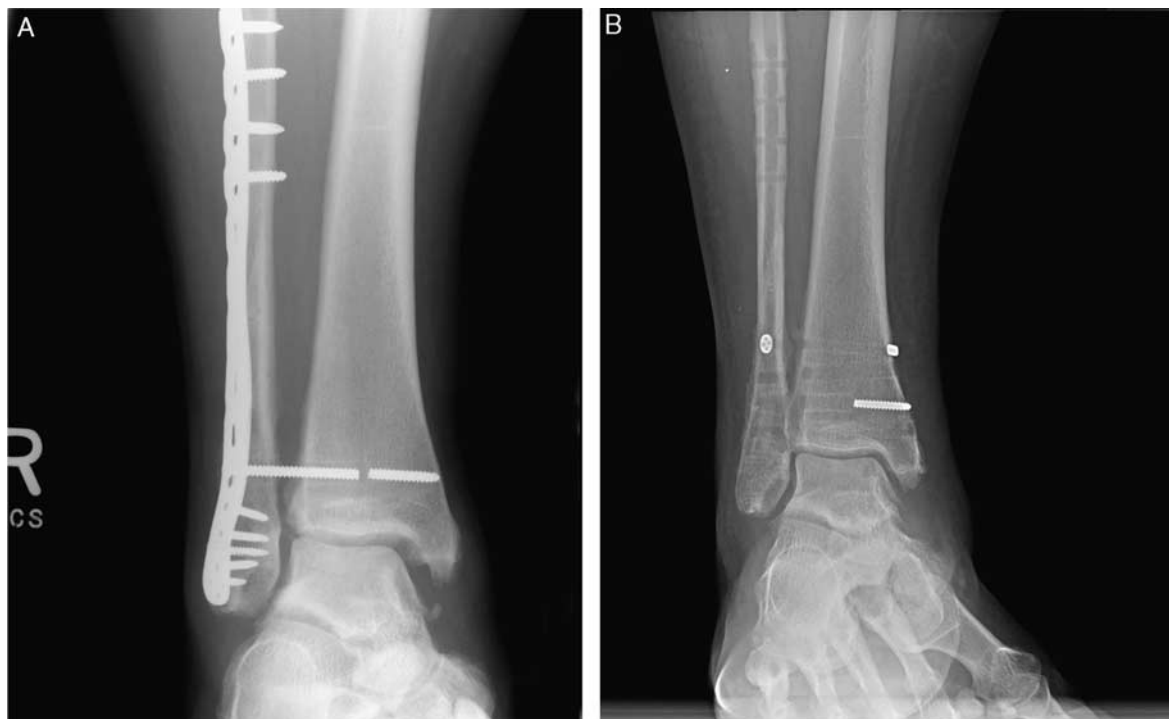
A, Preoperative mortise of a patient with failure of the syndesmotic fixation s/p open reduction and internal fixation. B, Six-month postoperative weight-bearing radiograph demonstrates stable reduction of the syndesmosis and medial clear space.
